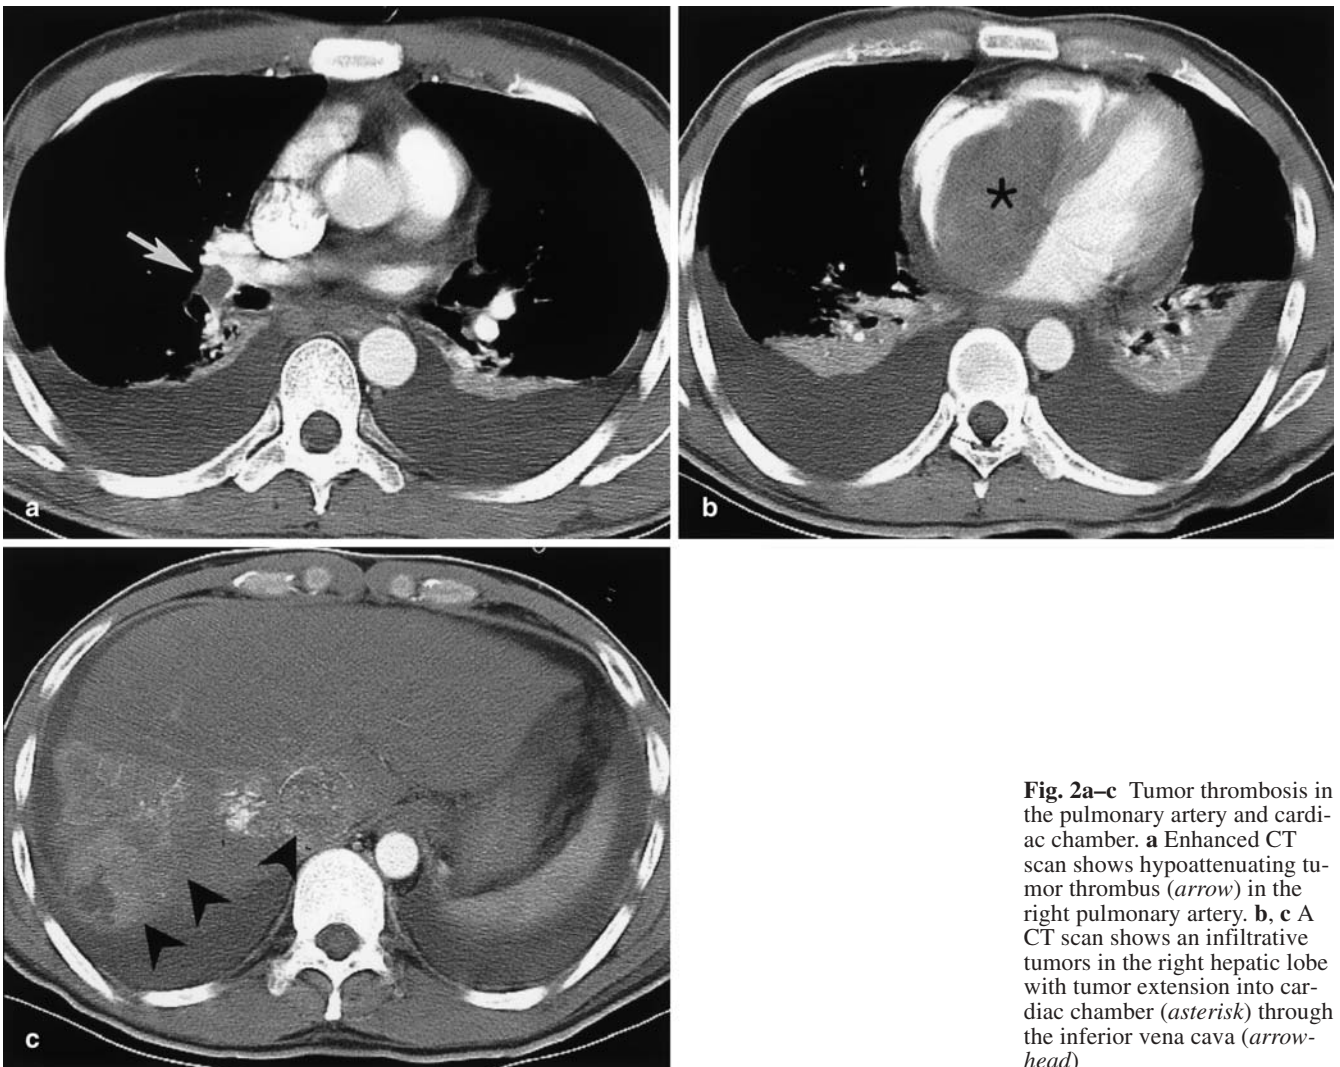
Tumor thrombosis in the pulmonary artery and cardiac chamber. a Enhanced CT scan shows hypoattenuating tumor thrombus (*arrow*) in the right pulmonary artery. b, c A CT scan shows an infiltrative tumors in the right hepatic lobe with tumor extension into cardiac chamber (*asterisk*) through the inferior vena cava (*arrow-head*)
